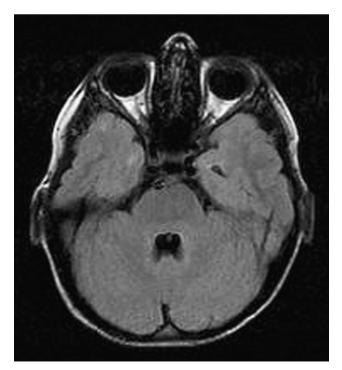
T2 FLAIR axial MRI on follow up is normal.
